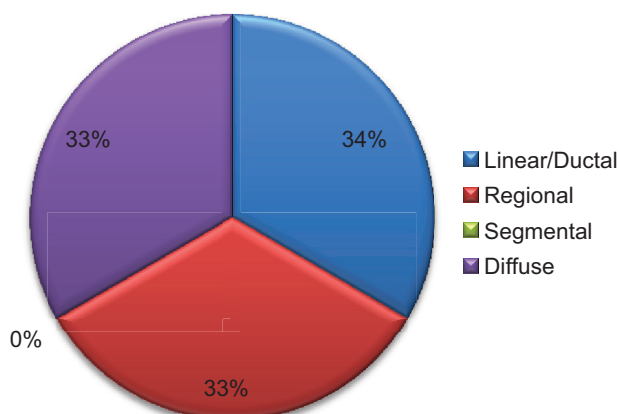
MRI description of non mass like enhancement.
